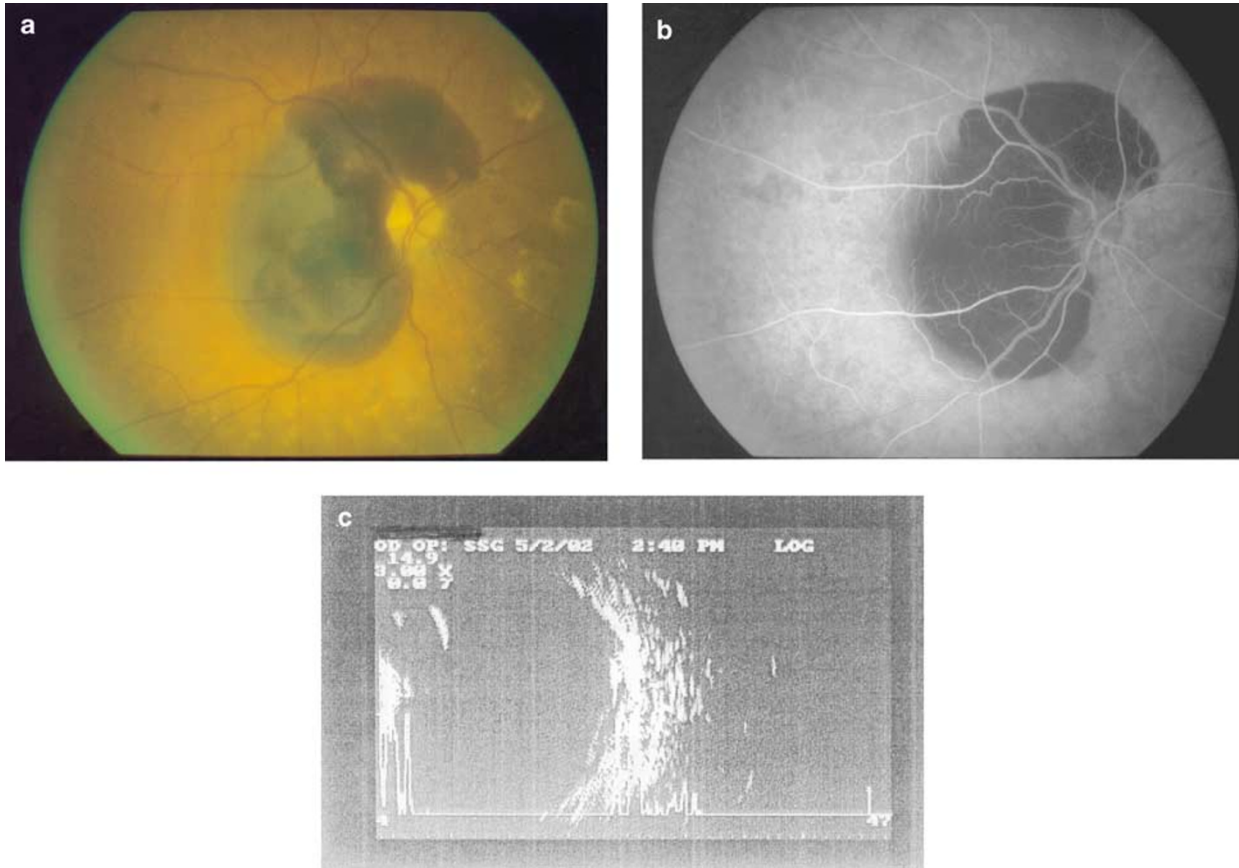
(a, b) Massive subretinal bleed in the right eye, involving the macula and the peripapillary areas and (c) B scan ultrasonography showing subretinal bleed.
